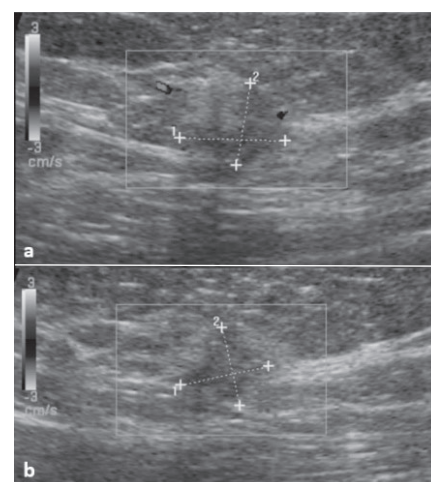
Ultrasound-guided core needle biopsy of a BI-RADS 5 lesion (a transverse image; b longitudinal image) in a 65-year-old woman showing benign papilloma without atypia, which was considered a radiologic-pathologic discordance. Upgraded diagnosis after surgical excision was ductal carcinoma in situ.
